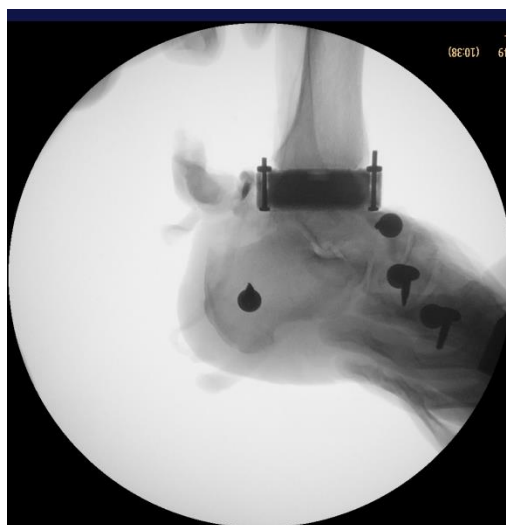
A lateral radiograph to determine the AP neutral position (this image has the fixture slightly too far posterior on the talus).
